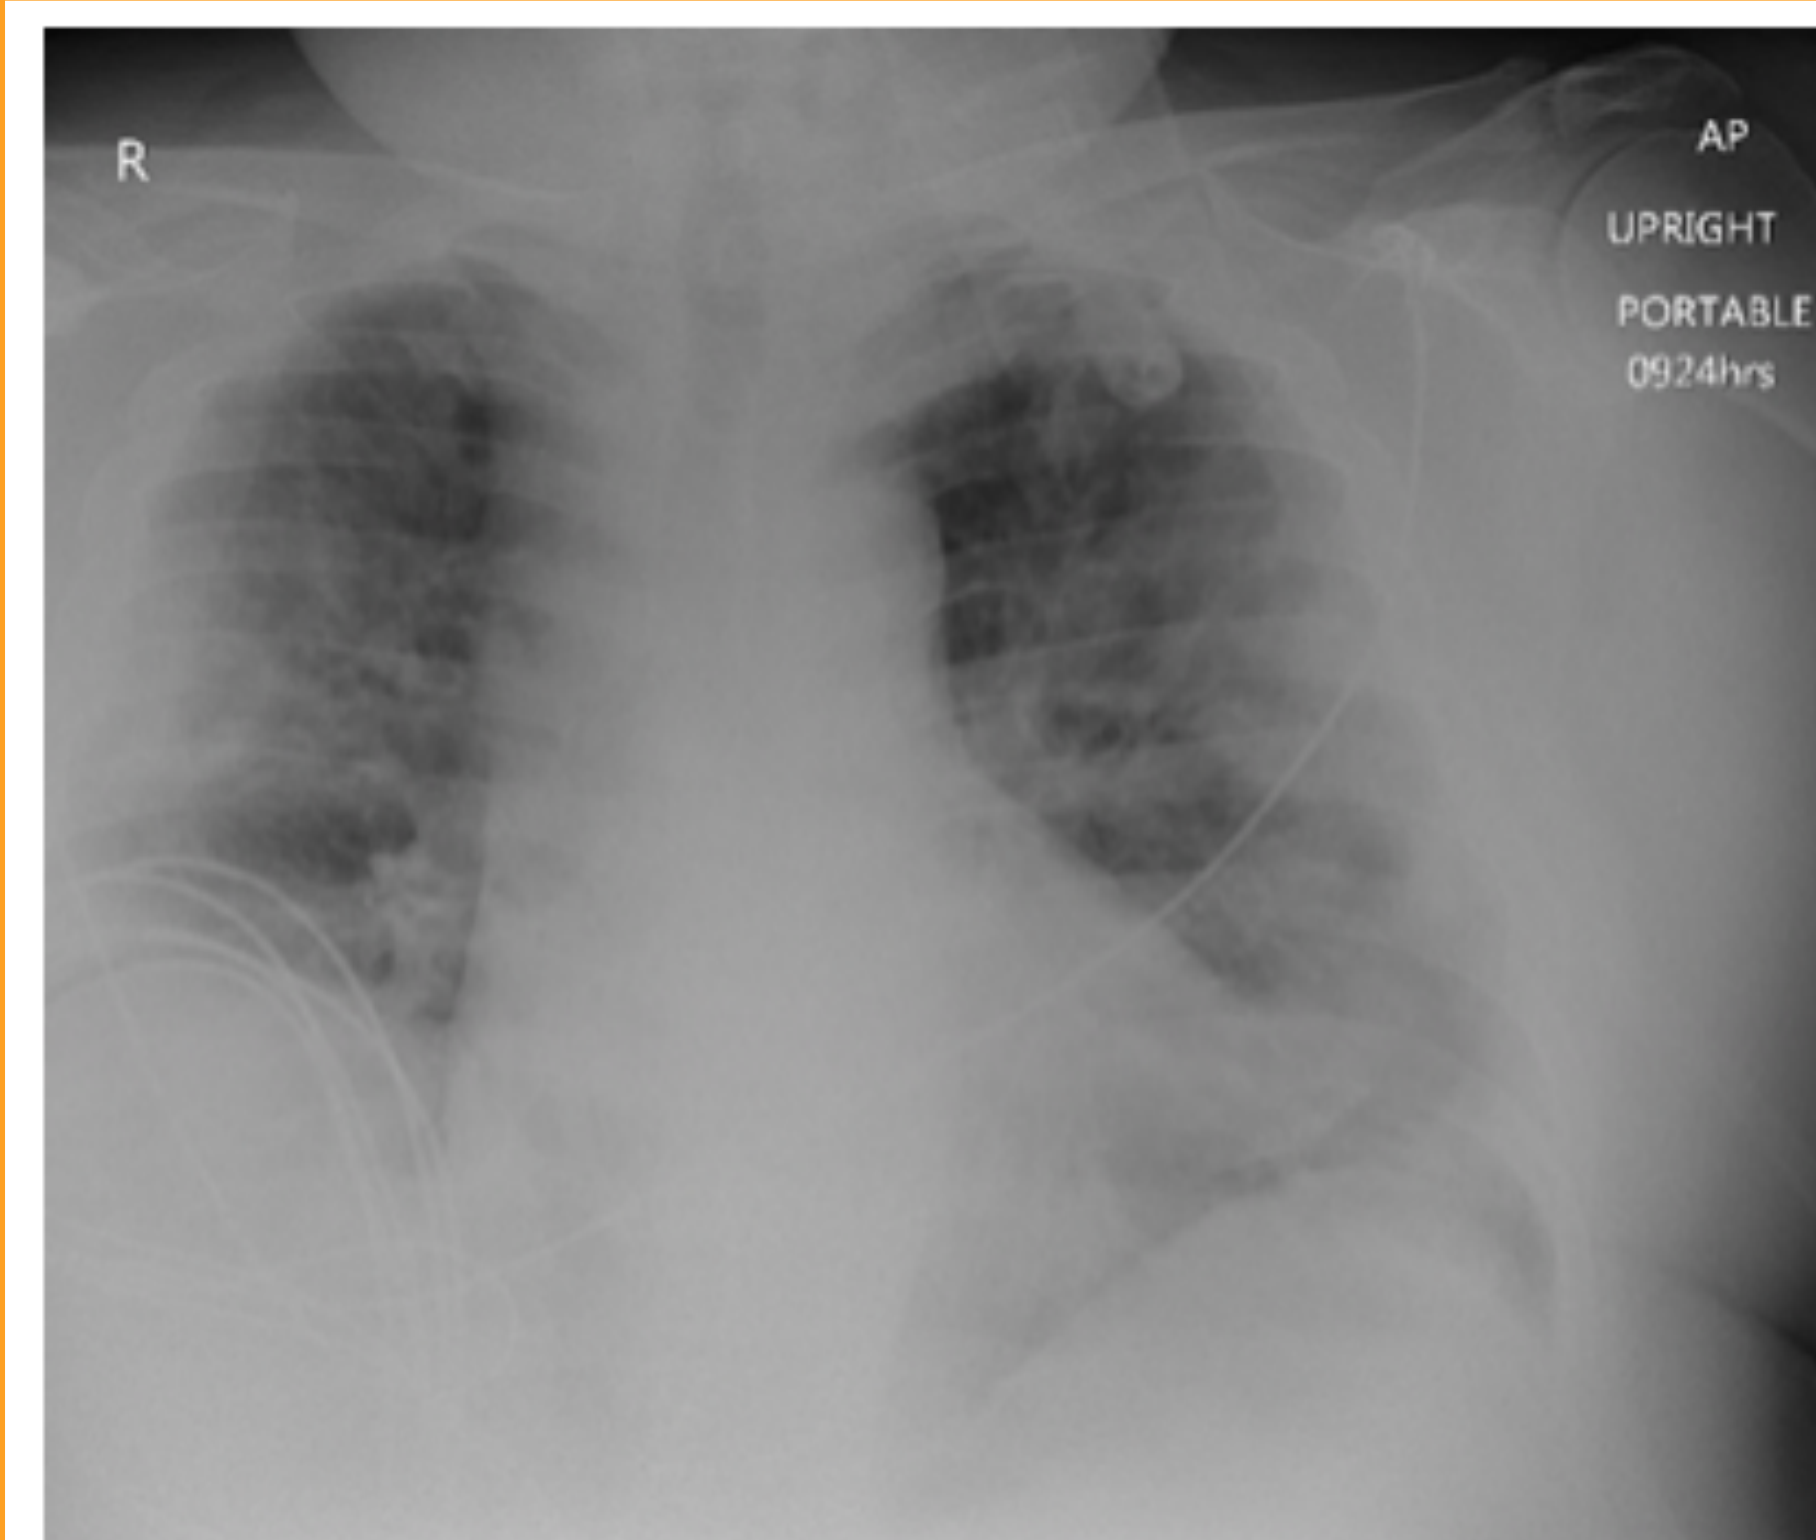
Patient's initial emergency department chest radiograph. Bilateral airspace consolidations with no acute osseous abnormalities are shown, a consistency found with acute respiratory distress syndrome.
